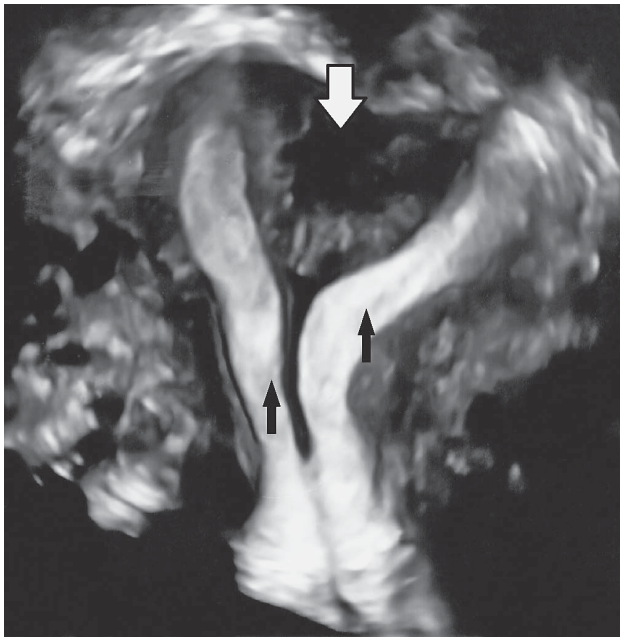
Axial ultrasound image demonstrating double uterine cavities (black arrows) and uterine septum (white arrow)
